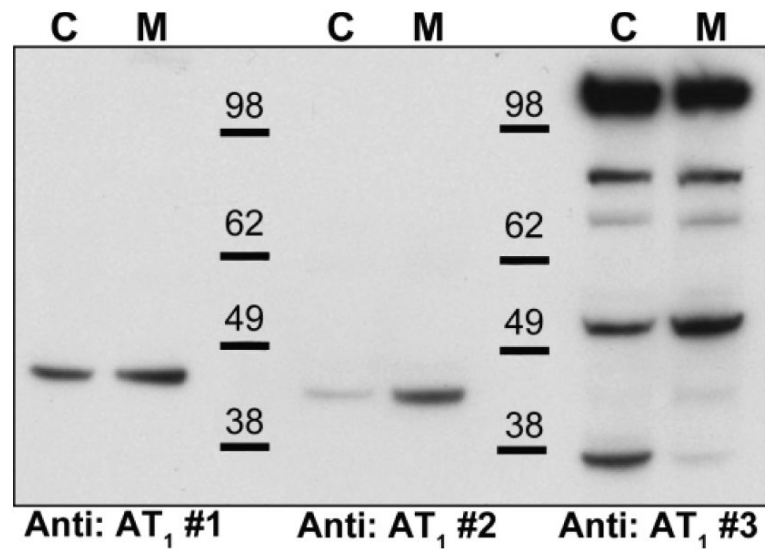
Western blot analysis of 40 μ g homogenates of kidney cortex (C) and medulla (M) using three different commercially available angiotensin type 1 receptor (AT₁R) antibodies. Antibody #1: Alomone AAR-011, antibody #2: Santa Cruz sc-1173 (n-10), antibody #3: Abcam 18801. X-ray films were exposed to the membranes for 2 min. Representative of $n = 2$.
